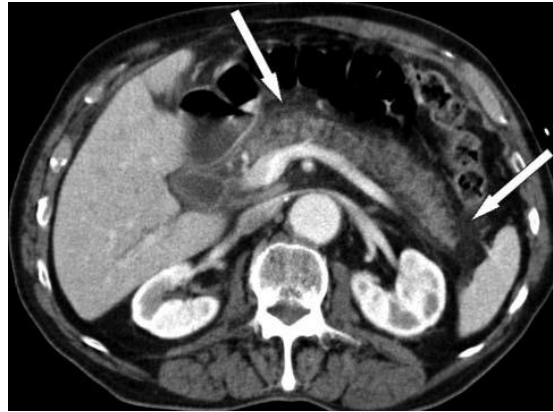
Acute interstitial oedematous pancreatitis on CT. There is peripancreatic fat stranding (arrows) without an acute peripancreatic fluid collection; the pancreas enhances completely but has a heterogeneous appearance due to oedema (Bharwani et al., 2011).
